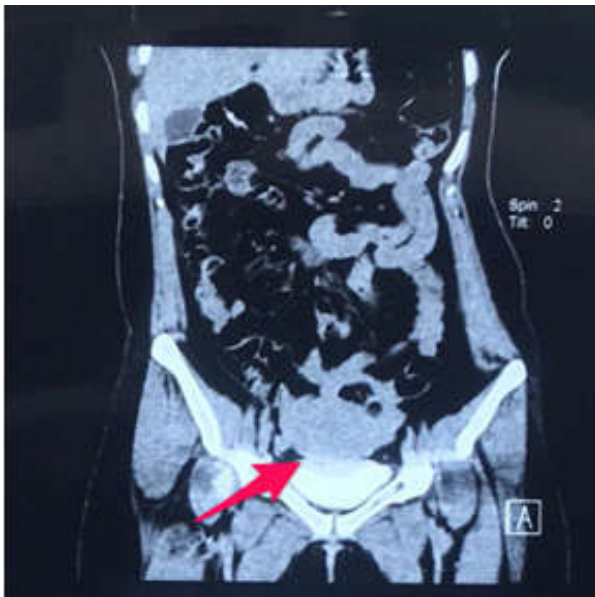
CT Scan - Arrow shows VUF
